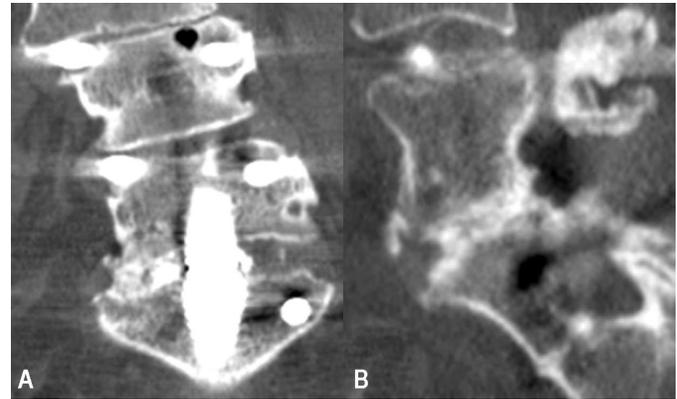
Example of axial lumbar interbody fusion. (A and B) Coronal and sagittal computed tomographic scans of a 72-year-old woman, 1 year after the procedure.
